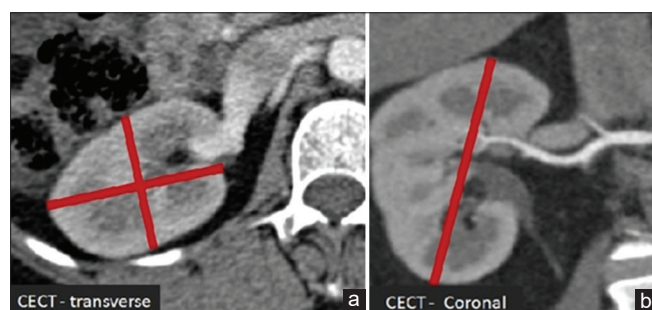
(a and b) Computed tomographic angiography coronal and transverse image showing the method of estimation of renal volume
